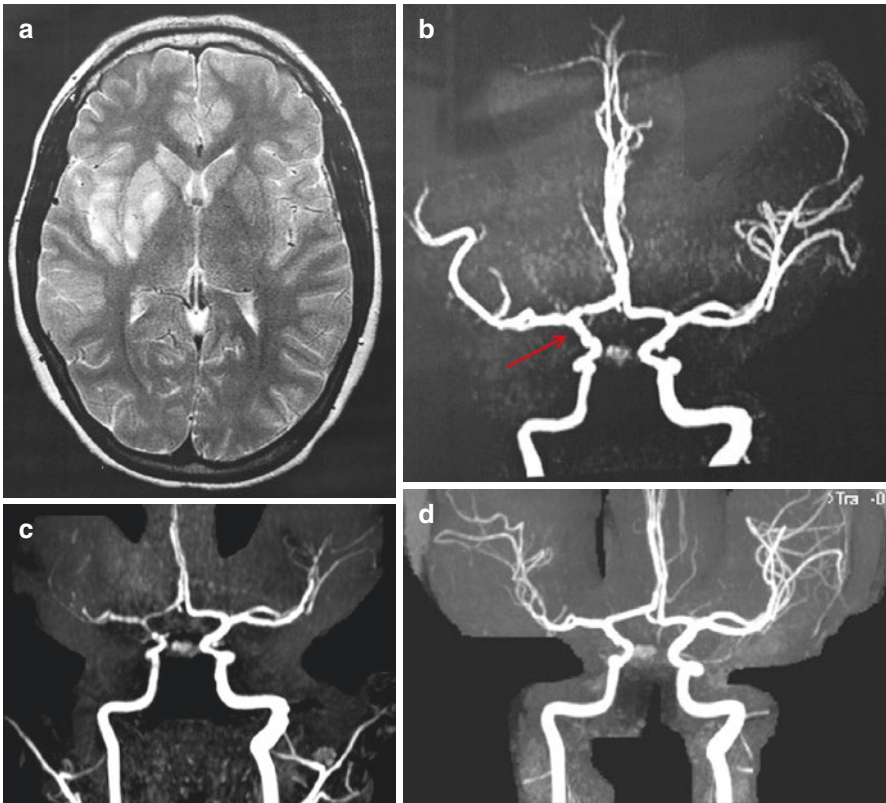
Fourteen year-old girl presents with acute onset left hemiparesis affecting the face, arm and leg. Baseline T2-weighted MRI demonstrating right MCA infarction involving the basal ganglia and adjacent cortex (a). MRA at the time of stroke recurrence demonstrating irregular segmental narrowing of the distal ICA, M1 and A1 (red arrow) consistent with beading (b). MRA at 3 months post-stroke demonstrating progression with reduced flow in the distal ICA, and proximal MCA and ACA (c). MRA at 2 years post-stroke demonstrating near complete resolution of arterial abnormalities, consistent with transient cerebral arteriopathy (d)
